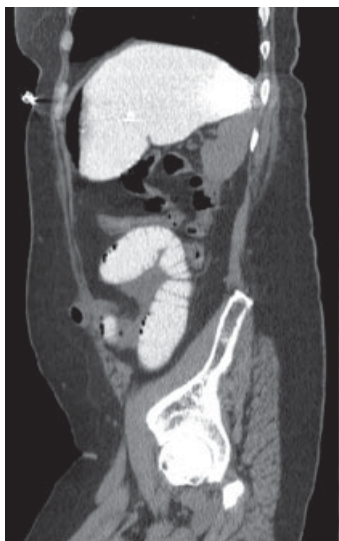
CT with oral contrast, sagittal view.
